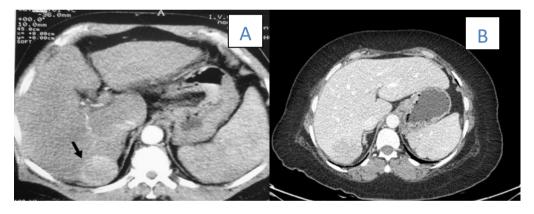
CT-Scan abdomen shows lesion in segment VII of liver measures approximately 4.2 x 5.0 x 4.5 cm (black arrow) showing enhancement in the arterial phase(A) with subsequent washout in the Porto venous(B) and delayed phase (C)
